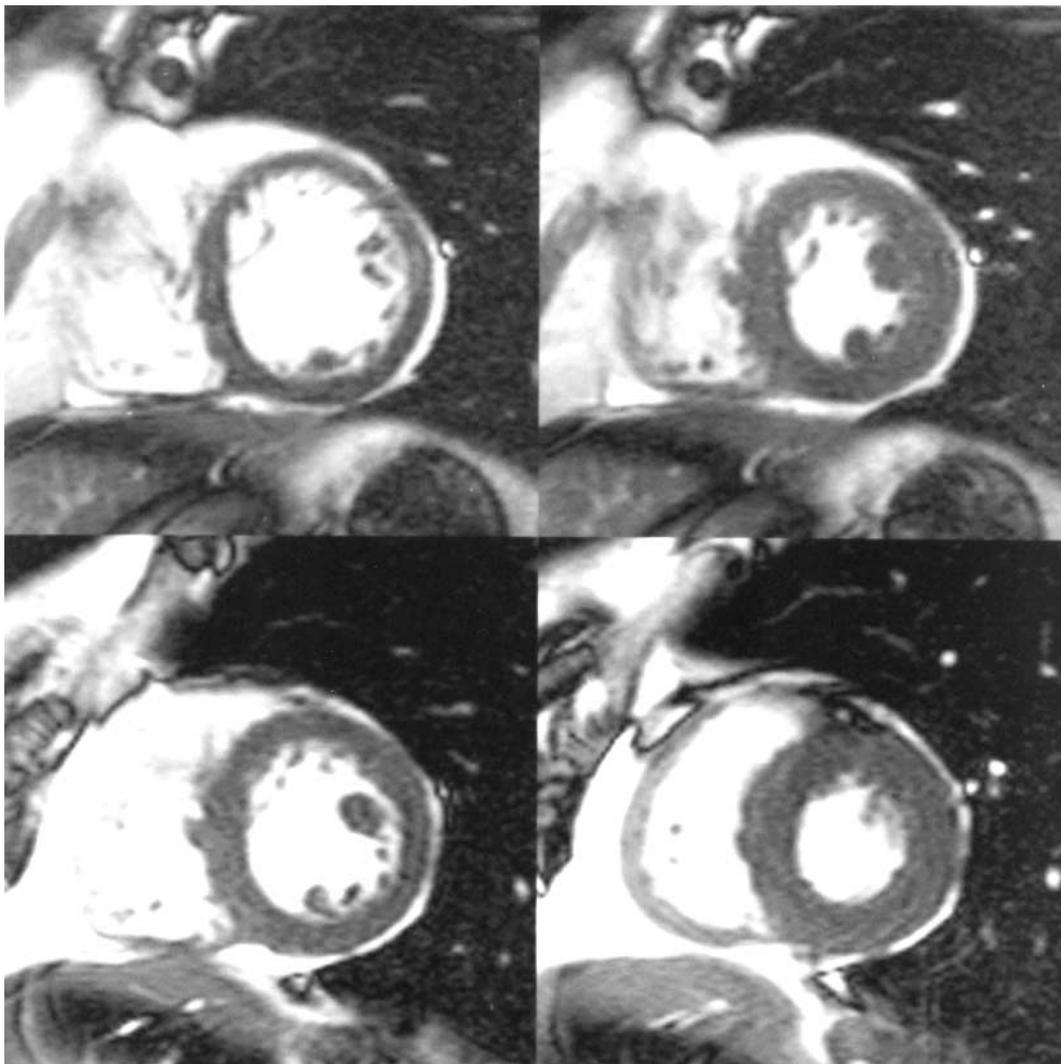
Same patient as Fig. 2: Comparable end-diastolic (left) and end-systolic, (right) short-axis, cine MR images, on which the volume evaluation was based. Above: before dialysis; below: after dialysis treatment. Note the decrease in left ventricular diameter after dialysis and the larger shift of the end-systolic image towards the valvular plane (no papillary muscles depicted) due to the shortened long-axis diameter of the ventricle with lower volumes.
